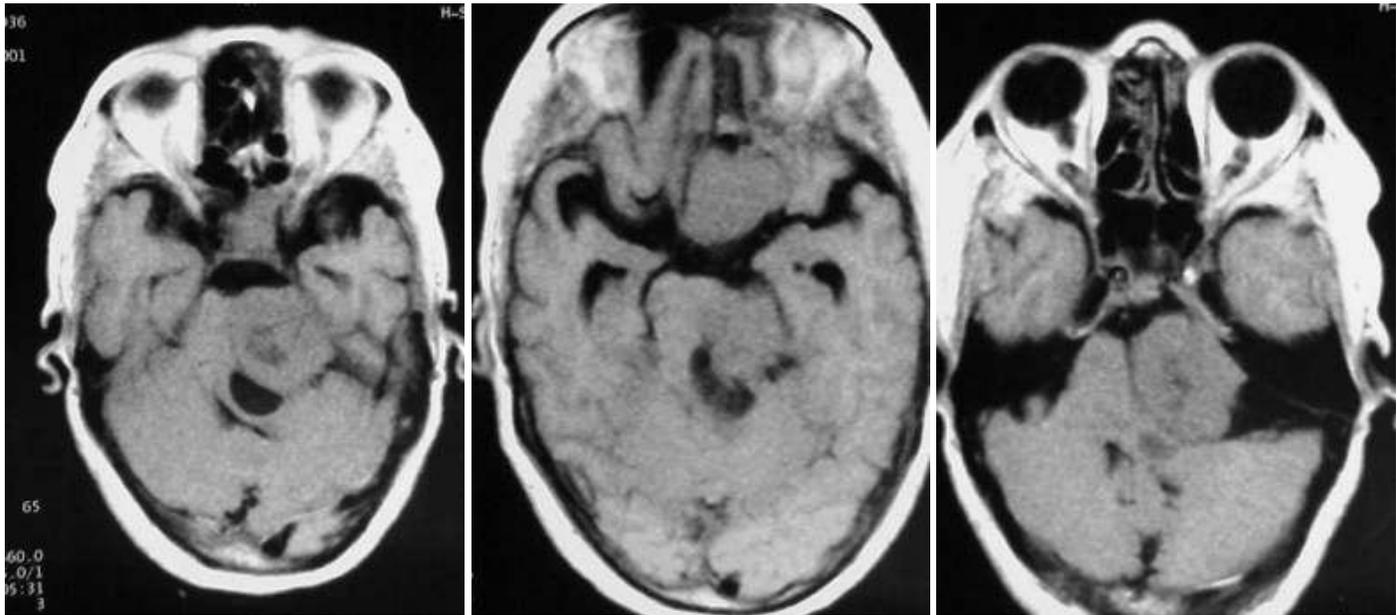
Two syncytial meningiomas. Precontrast MRI T1 images showing two lobulated space occupying lesions in the parasellar/subfrontal and the cerebellopontine regions. The lesions are surrounded by a CSF cleft and a large cyst is seen in the cerebellopontine lesion. Both lesions are isointense to slightly hypointense relative to normal brain tissues. The 4TH ventricle is compressed and pushed posteriorly and to the right. A large arachnoid cyst is seen along the right posterior pole of the cerebellopontine angle mass.
